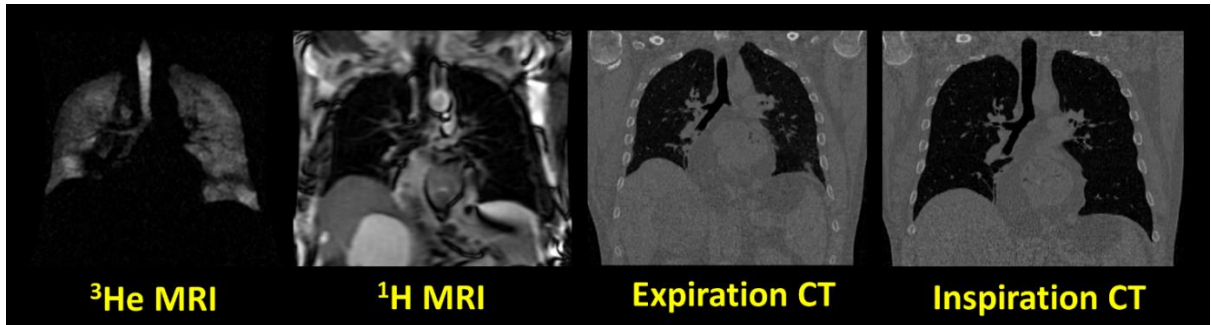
Coronal slices for same-breath ^3He and ^1H MRI and inspiration and expiration CT.
